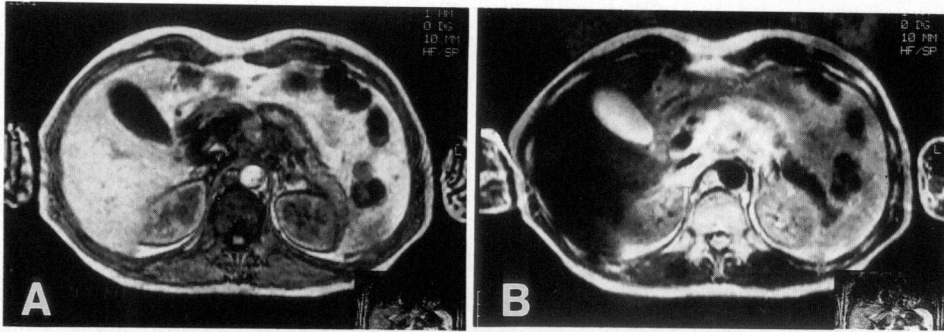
MR imaging of hepatocellular carcinoma.
